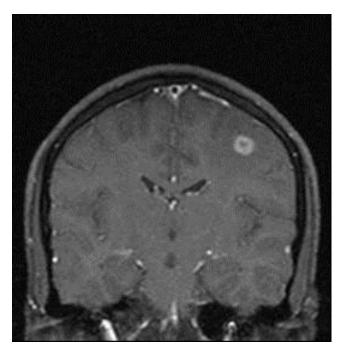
MRI Brain image showing tuberculoma lesion in left cerebral hemisphere
